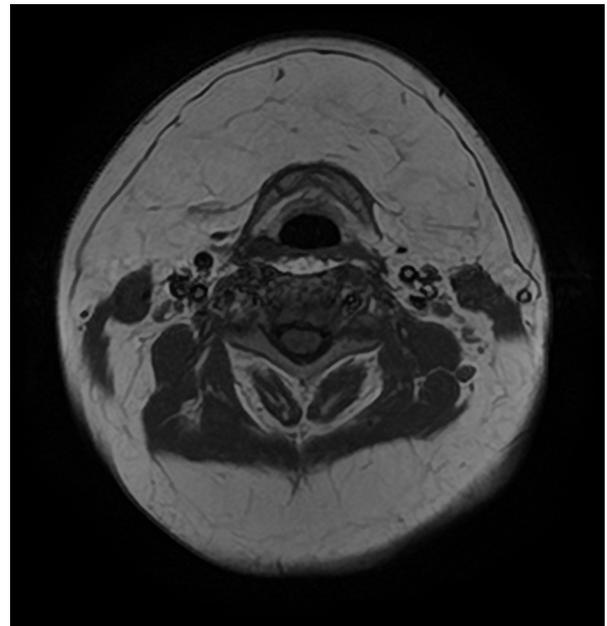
Magnetic resonance imaging of the head and neck showed nonencapsulated soft tissue masses dispersed over the superficial and deep fascial spaces.
